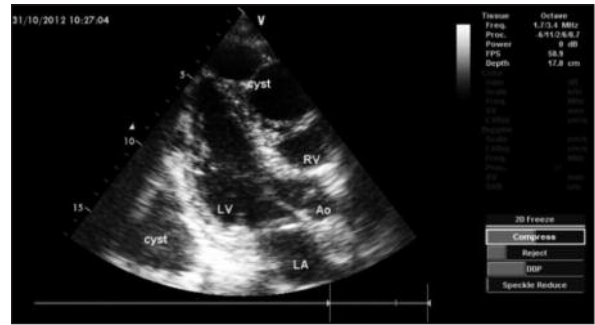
Transthoracic echocardiography of the patient reveals cystic lesions located posteriorly to left ventricle, and adjacent to apical portion of right ventricle. LV: Left ventricle; LA: Left atrium; Ao: Aorta; RV: Right ventricle.
